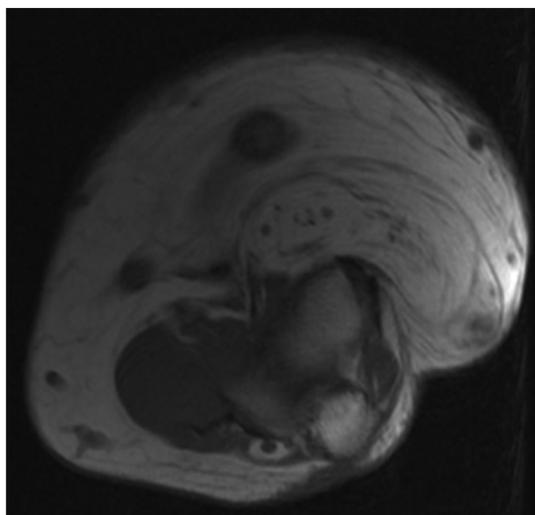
MRI T1-Fatsat axial view with gadolinium injection. The radial nerve appears like a “spaghetti sack”. In T1 sequences, fatty tumour tissue is hyperintense and the fascicles, hypointense.
